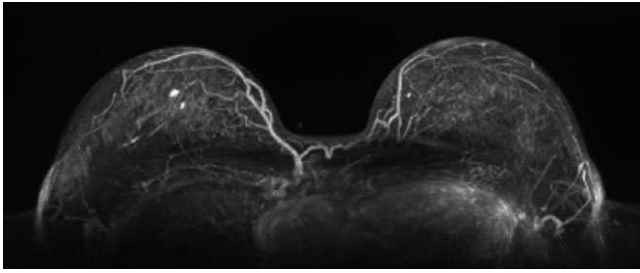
Maximum intensity projection from a MR image. The T1-weighted acquisition was performed using a gadolinium-based agent. The last 3D image was subtracted to the initial precontrast 3D image and the maximum intensity pixel values were projected in the superior–inferior direction using MeVisLab™.
